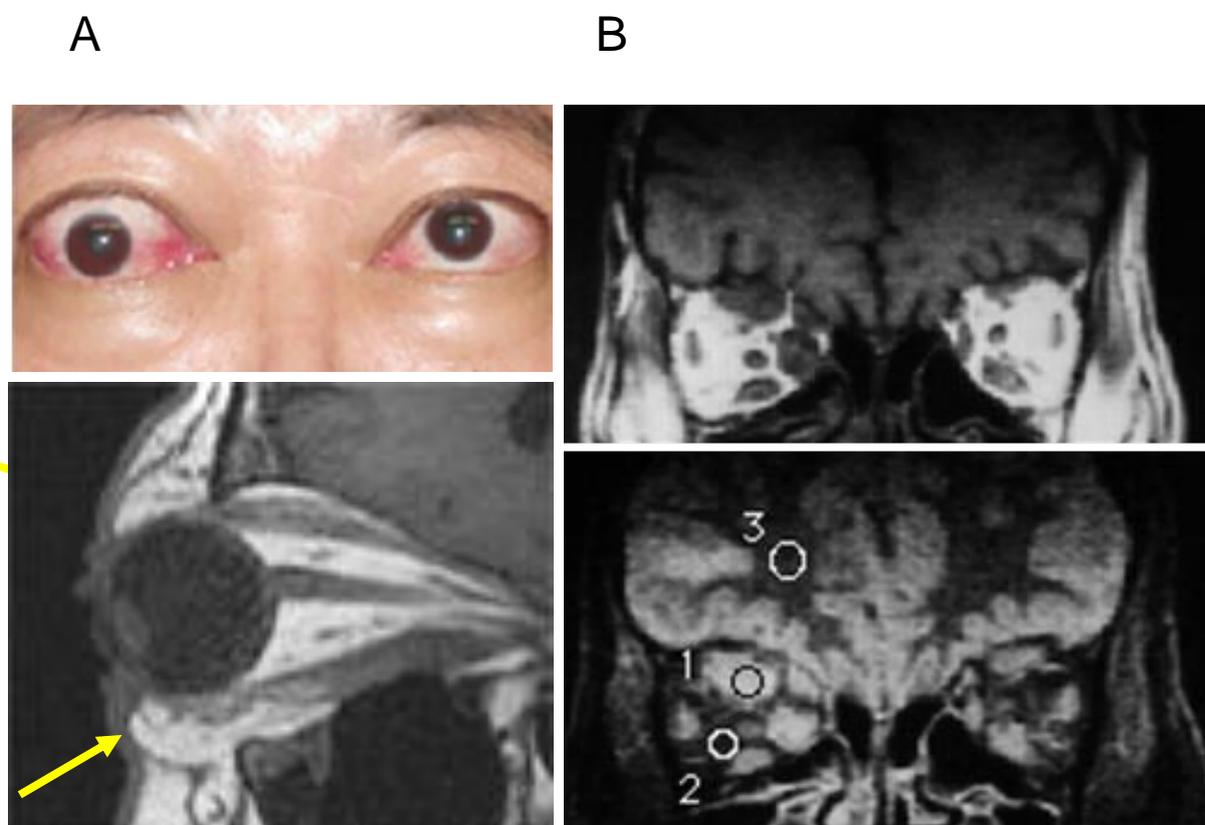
Orbital MRI before steroid pulse therapy for patients with diplopia. A: Patient with diplopia; MRI reveals the enlargement of superior and inferior rectus muscles, proptosis and the accumulation of fat tissue in the eyelids B: Another patient with diplopia; upper snapshot, coronal section of T1-weighted image; lower snapshot, coronal section of STIR image Open circles shows the area where the signal intensity is measured. 1, orbital connective tissue; 2, eye muscle; 3, cerebral substantia alba.(modified from ref. # 11).
